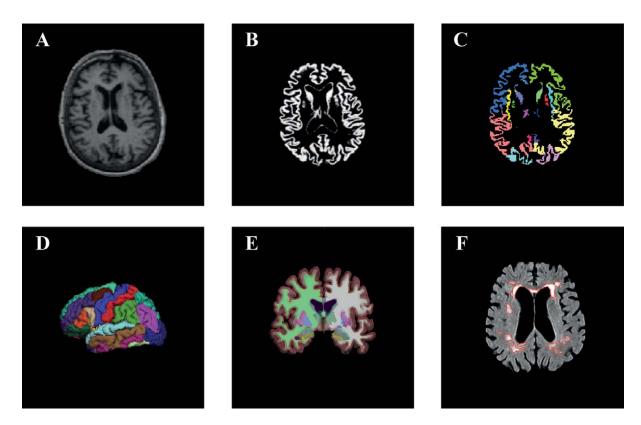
Examples of input features for classifiers. A) An original axial T1-weighted MR image. B) Grey matter segmentation using SPM. C) Parcellated ROIs after registration image B to an atlas. D) Cortical parcellation using Freesurfer. E) Subcortical and cortical segmentation using Freesurfer. F) White matter segmentation using the Cascade software (http://git.io/cascade) [127].
